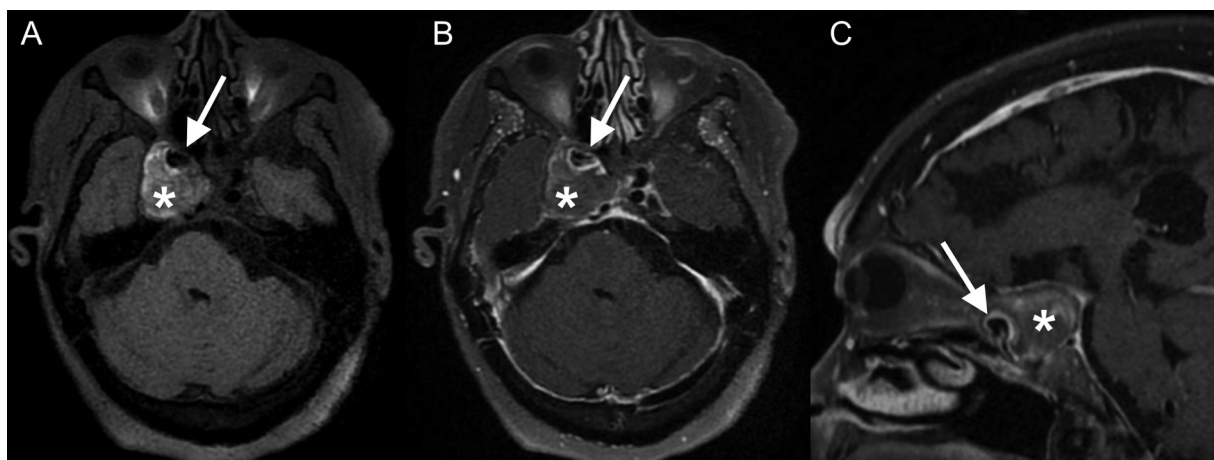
Pre- (A) and postgadolinium vessel wall magnetic resonance images (B-C) showing the expected flow void of the parent aneurysm (arrow in A) and the giant non-enhancing thrombosed eccentric component (asterisks). Notice the thickened and enhancing wall of the parent internal carotid artery (arrows in B and C).
